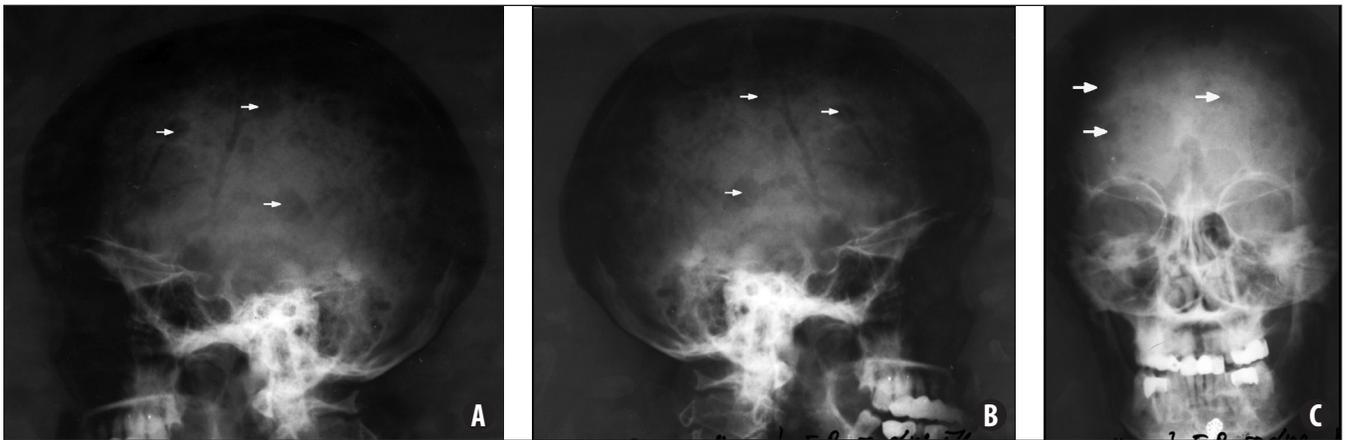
X-ray photos of skull in sagittal left (A), right (B) and front (C) views.
